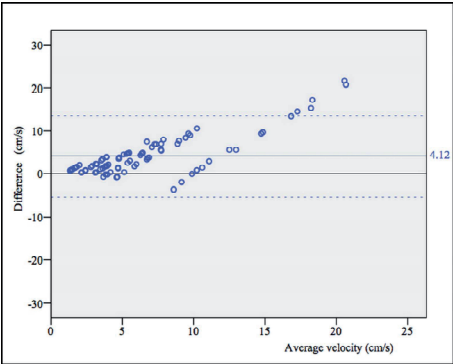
Agreement between true velocity and Doppler velocity. Bland-Altman plot of agreement between true velocity (V_{true}) and velocity estimated by Doppler measurements ($V_{measured}$). The mean difference is 4.12 cm/s (95%CI 3.10 - 5.15 cm/s), dotted lines represent ± 2 standard deviation borders.
